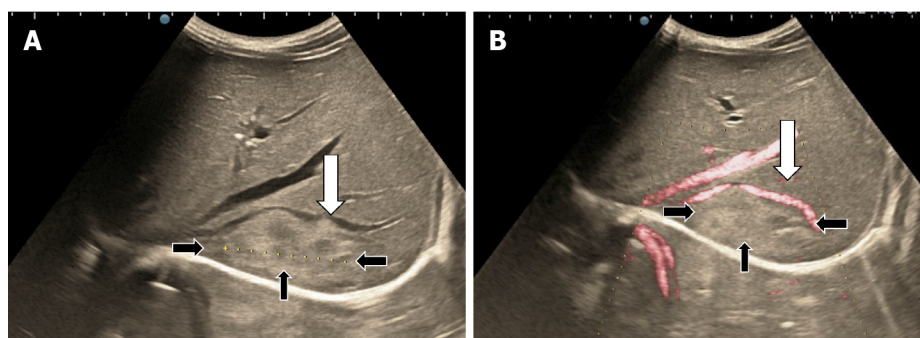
Subdiaphragmatic hepatic hemangioma (white arrows) that pushes the right hepatic vein (black arrows) without its invasion or thrombosis. A: B-mode ultrasound; B: Doppler ultrasound mode.
